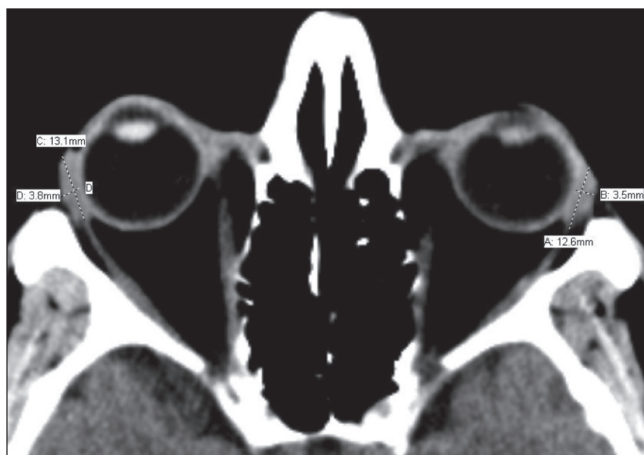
Axial CT of the lacrimal glands showing the anteroposterior diameters (lines A and C) and transverse diameters (lines B and D)
